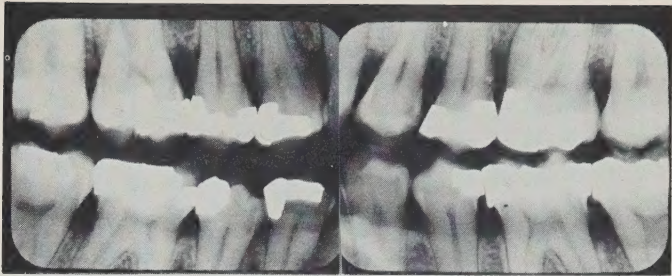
Interproximal "bite-wing" roentgenographs showing resorption of interalveolar crestal bone in periodontitis.
